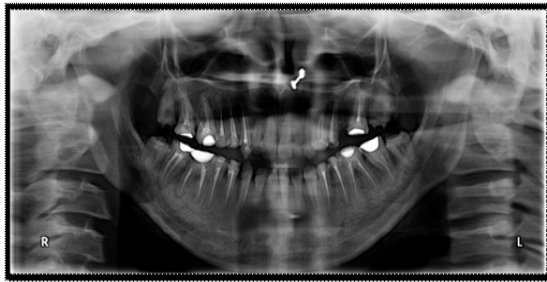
Radiograph prior to periodontal treatment
